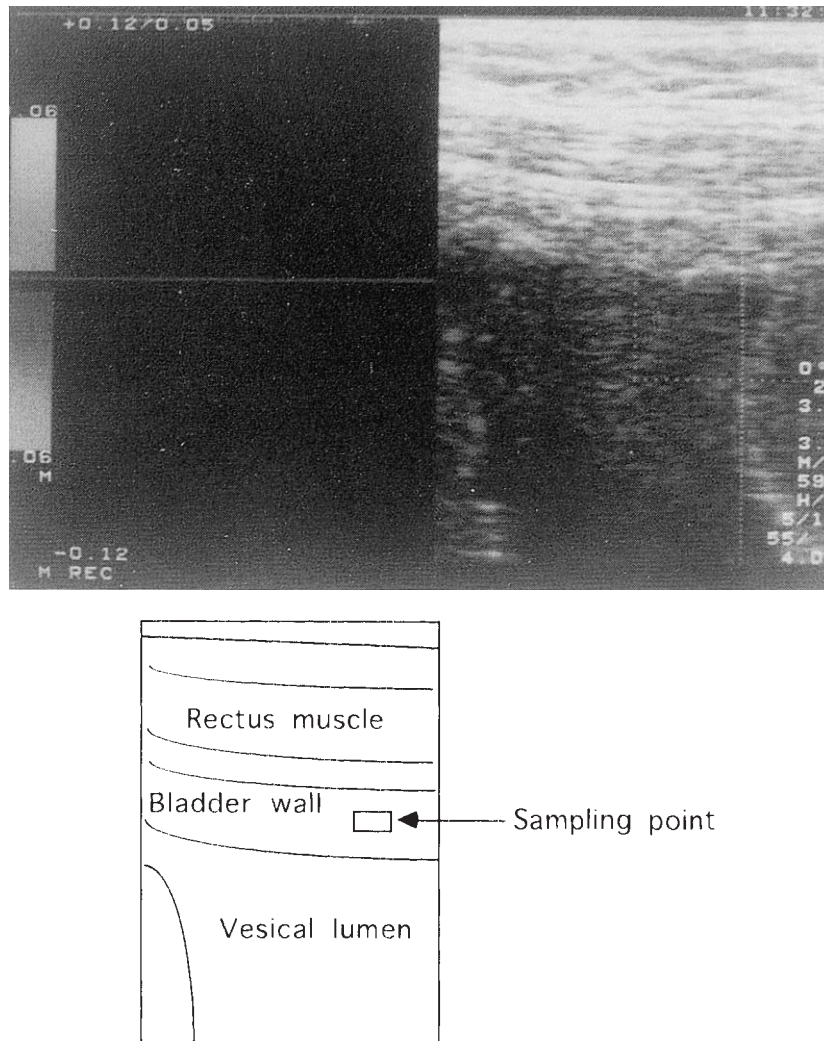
Color Doppler flow image of the anterior bladder wall in a 71 year-old female patient with neurogenic bladder dysfunction with underactive detrusor. The ultrasound estimated bladder weight was 52.2 g. No blood flow was detected.
